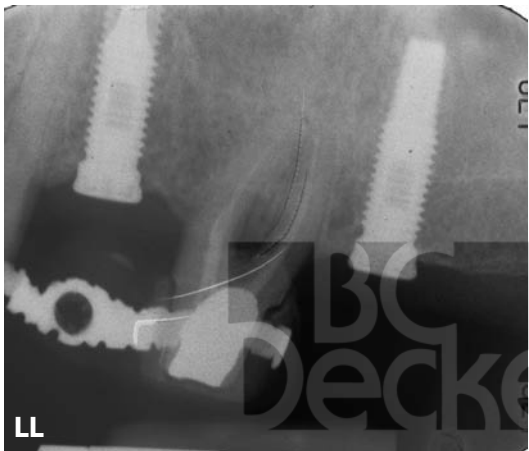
Continued. KK, Implants at the time of surgery. LL, Final healing with the immediate or staged procedure. MM, Final healing with the immediate or staged procedure. NN, Implants exposed 10 to 12 months later. OO, Tooth 14 extracted. Note the height of the bone in this area. Compare with B. PP, Implant temporization immediately after extraction followed by staged implant placement. QQ and RR, Final prosthetics inserted. SS, Final radiograph.
